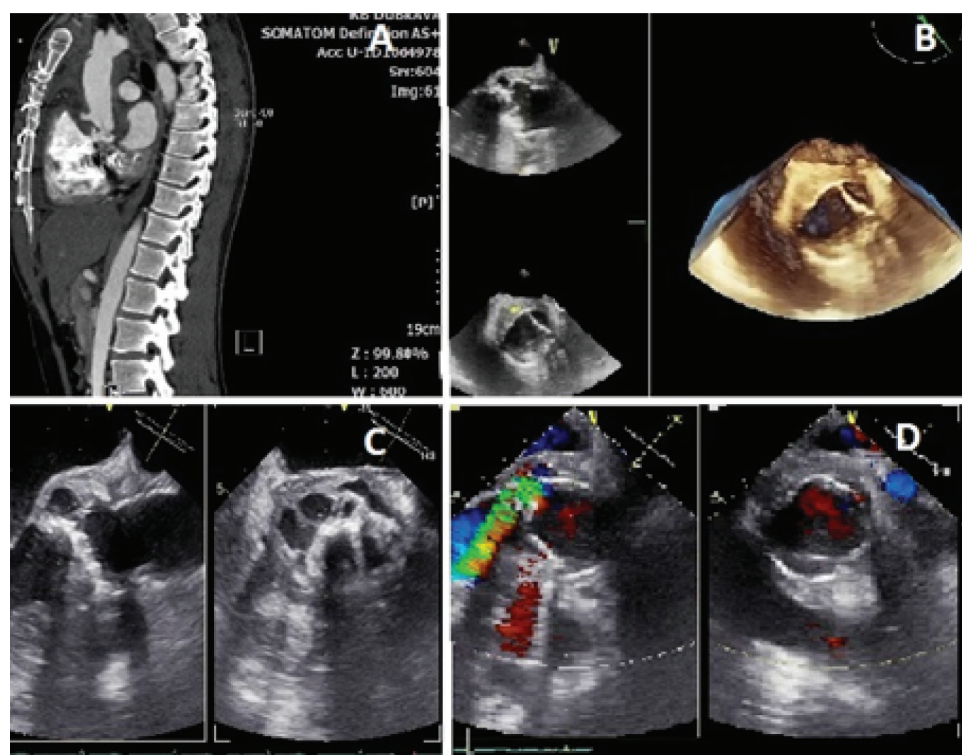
A MSCT aortography showing complex aortic root abscess, B 3D TEE of aortic root showing patch plastic protruding into aortic lumina, C, D multiplane transoesophageal echocardiography showing paraannular aortic abscess with paraannular regurgitant jet.
